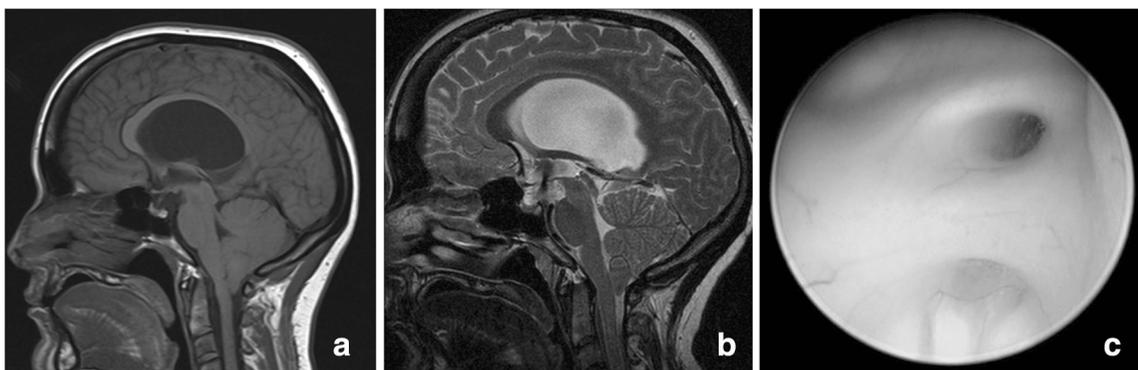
Sagittal T1-weighted image a of a 35-year-old female with Chiari malformation, history of headaches, memory issues, and elevated head circumference, harboring primary agenesis of the septum pellucidum (PAS, not shown) and a solitary, large interhypothalamic adhesion (IHA) attached to the third ventricular floor (limited preoperative imaging
